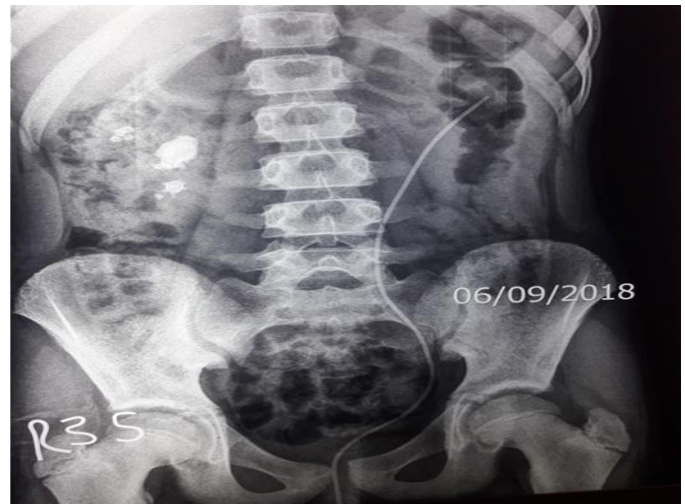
Postoperative x-ray KUB
